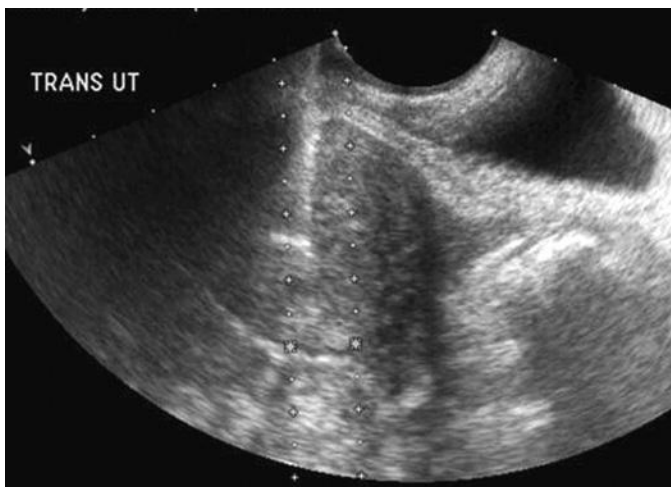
Unusual transuterine approach for endometrial biopsy. Because of marked cervical stenosis, an endometrial biopsy catheter could not be introduced through the cervical canal into the uterus. Real-time transvaginal sonographic guidance was used during sampling of the endometrium, performed after advancing a cutting needle through the uterine serosa and myometrium. Pathologic examination revealed endometrial adenocarcinoma. The echogenic vertical line situated between the guiding dotted lines represents the 18-gauge core biopsy needle.
